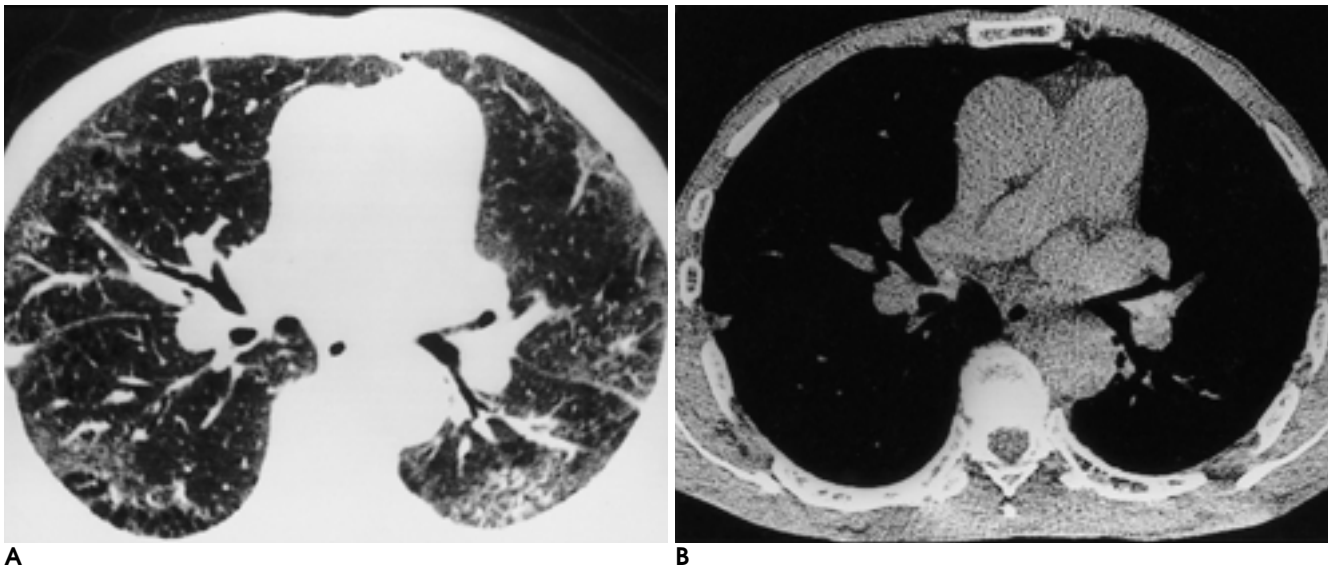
CT scans with lung windows (A) and mediastinal windows (B) of a 59-year-old female patient who presented dyspnea on exertion show no evidence of endobronchial lesion on the right middle lobar bronchus on which a fine endobronchial nodule was detected by bronchoscopy. Initially, sputum cytology revealed negative for malignancy and plain chest radiograph showed diffuse interstitial disease pattern. Bronchial washing cytology and bronchoscopic biopsy demonstrated squamous cell carcinoma. The tumor measured 0.2 cm and surgical stage was T1N0M0.
